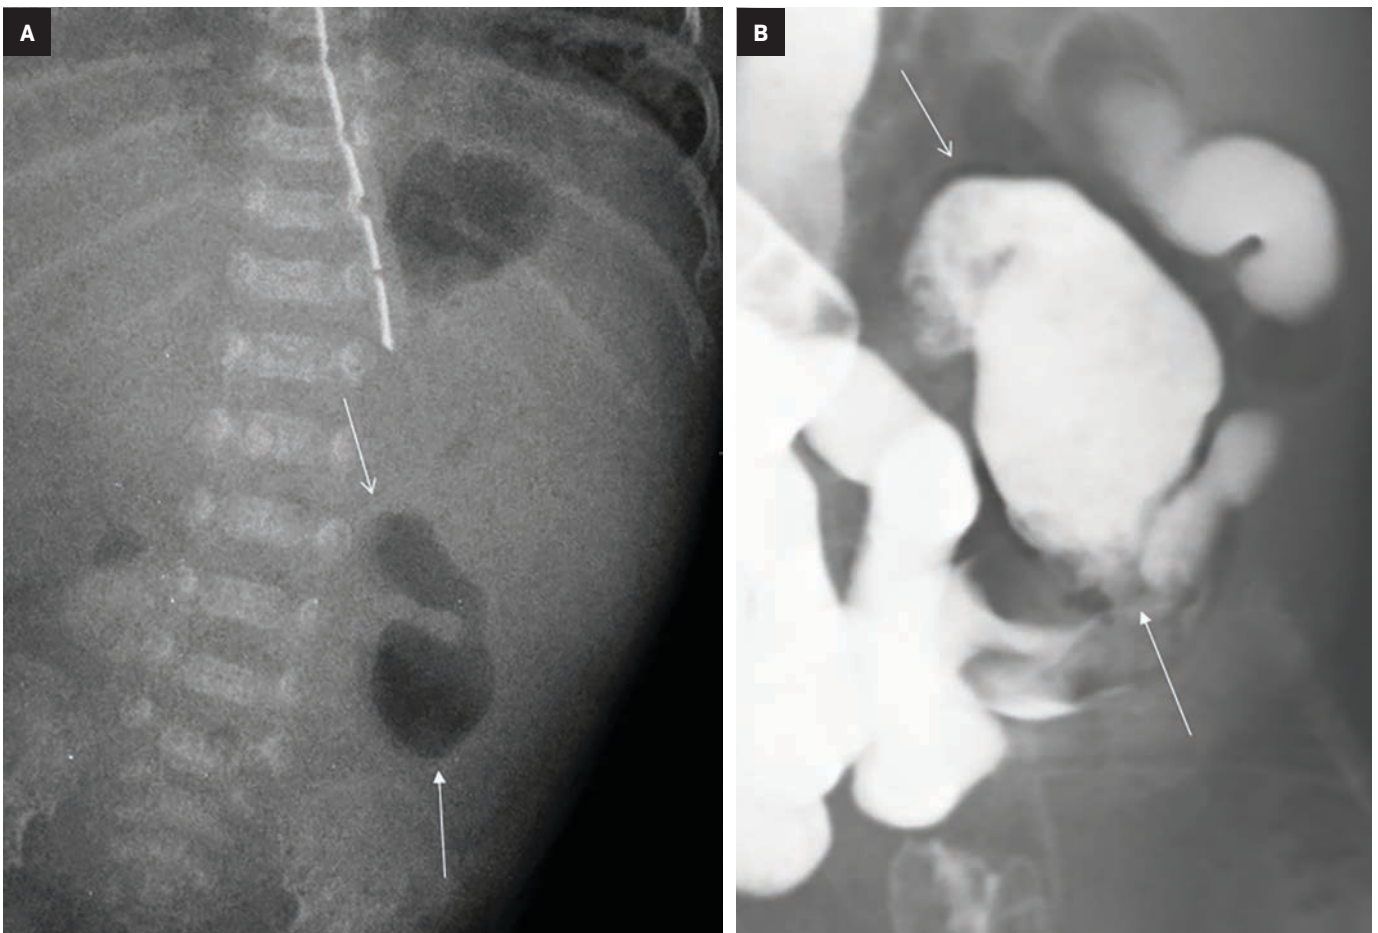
Radiological presentation of a GSD type 3 in a newborn. (A) Abdominal radiograph shows a saccular gas collection in the left lower abdomen (arrows). (B) Barium enema examination reveals a communicating GSD (arrows) which was surgically confirmed.
